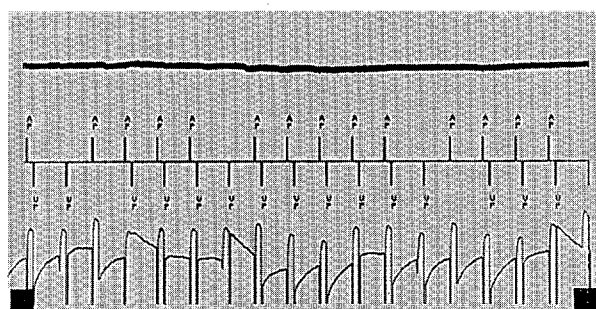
Interference of bipolar pacemaker activity during operation of ultrasonic bath cleaner. Irregular atrial and ventricular pacing and erratic output are noted.
